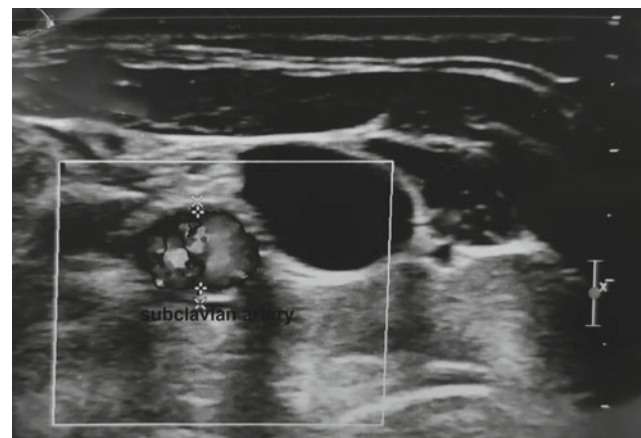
Duplex ultrasound. 45% stenosis of the subclavian artery
